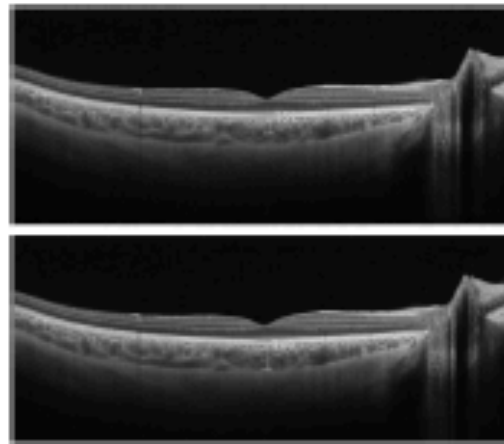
SS-OCT image of large choroidal vessel measuring 100 μ m or more within the closest proximity to the location of the subfoveal CT measurement point (top). The distance from their innermost edge to the choroid/sclera junction was calculated to obtain the Haller's layer thickness (bottom). The measurements of this layer were subtracted from the total CT at all nine measurement locations to obtain the choriocapillaris plus the Sattler's layer thicknesses.
